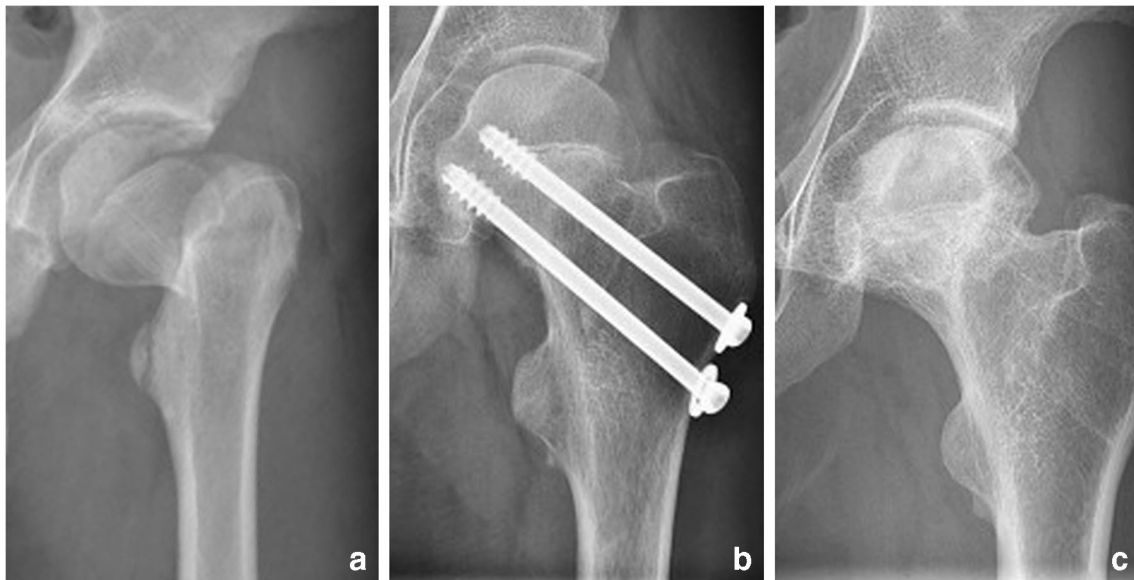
Radiographs of a 10-year-old girl with a displaced femoral neck fracture. a Anteroposterior (AP) view of a Delbet-Colonna type-II fracture, with the amount of initial translation (T_{AP}) over 37.4%. b AP
